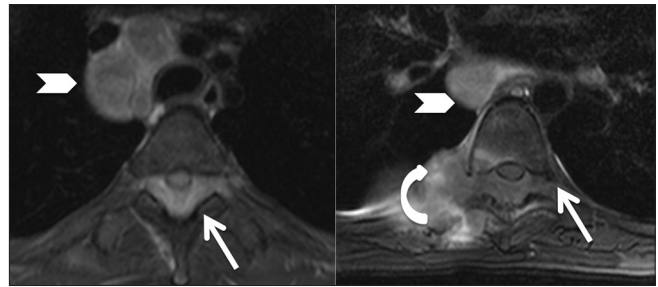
Infective: Tuberculosis: Axial T2-weighted images at upper and lower thoracic levels, showing large posterior epidural abscess (arrow) compressing the cord anteriorly and extending into both the intervertebral foramina. Right costovertebral joint is involved with adjacent soft tissue (curved arrow). Enlarged mediastinal nodes are seen (arrowhead)
